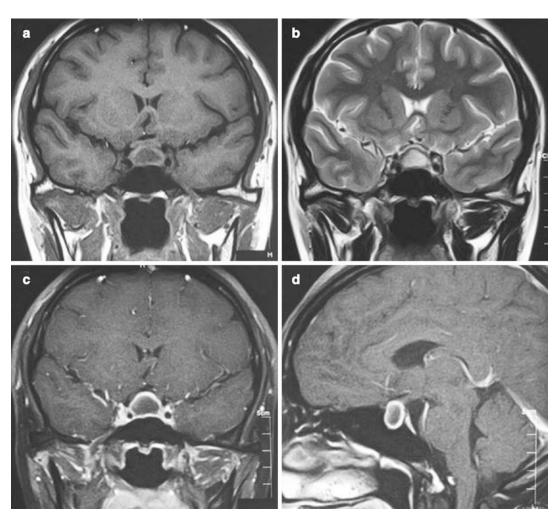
Typical MRI findings in a patient with a pituitary abscess. (a) T1-weighted MRI shows hypointense and isointense signals (coronal). (b) T2-weighted MRI shows hyperintense and isointense signals (coronal). (c)
